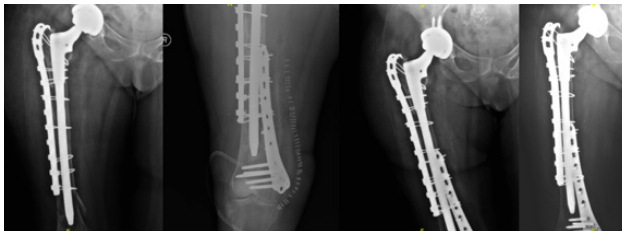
A 76-year-old female patient falls 1 month after revision hip replacement surgery and has a Vancouver type B1 periprosthetic fracture. Cable-plate fixation is applied to the patient. The patient, who was followed up for 1 year, died due to heart diseases for primary coxarthrosis. He had a Vancouver type B1 periprosthetic fracture after a fall 2 months after the operation. Cable-plate fixation application to the patient and the radiograph showing the union after 6 months.
